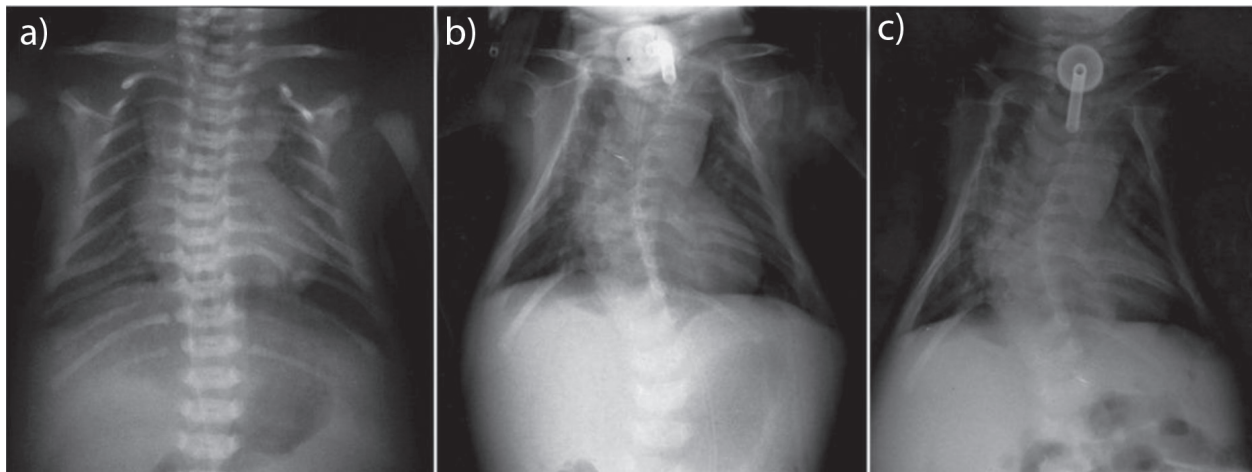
Chest X-rays of the infant showing 11 pairs of ribs, posterior rib-gap defects on the 2nd–9th rib bilaterally, narrow ribcage and spine deformity. Photographs were taken at the age of (a) one day, (b) four months, and (c) 6.5 months.
